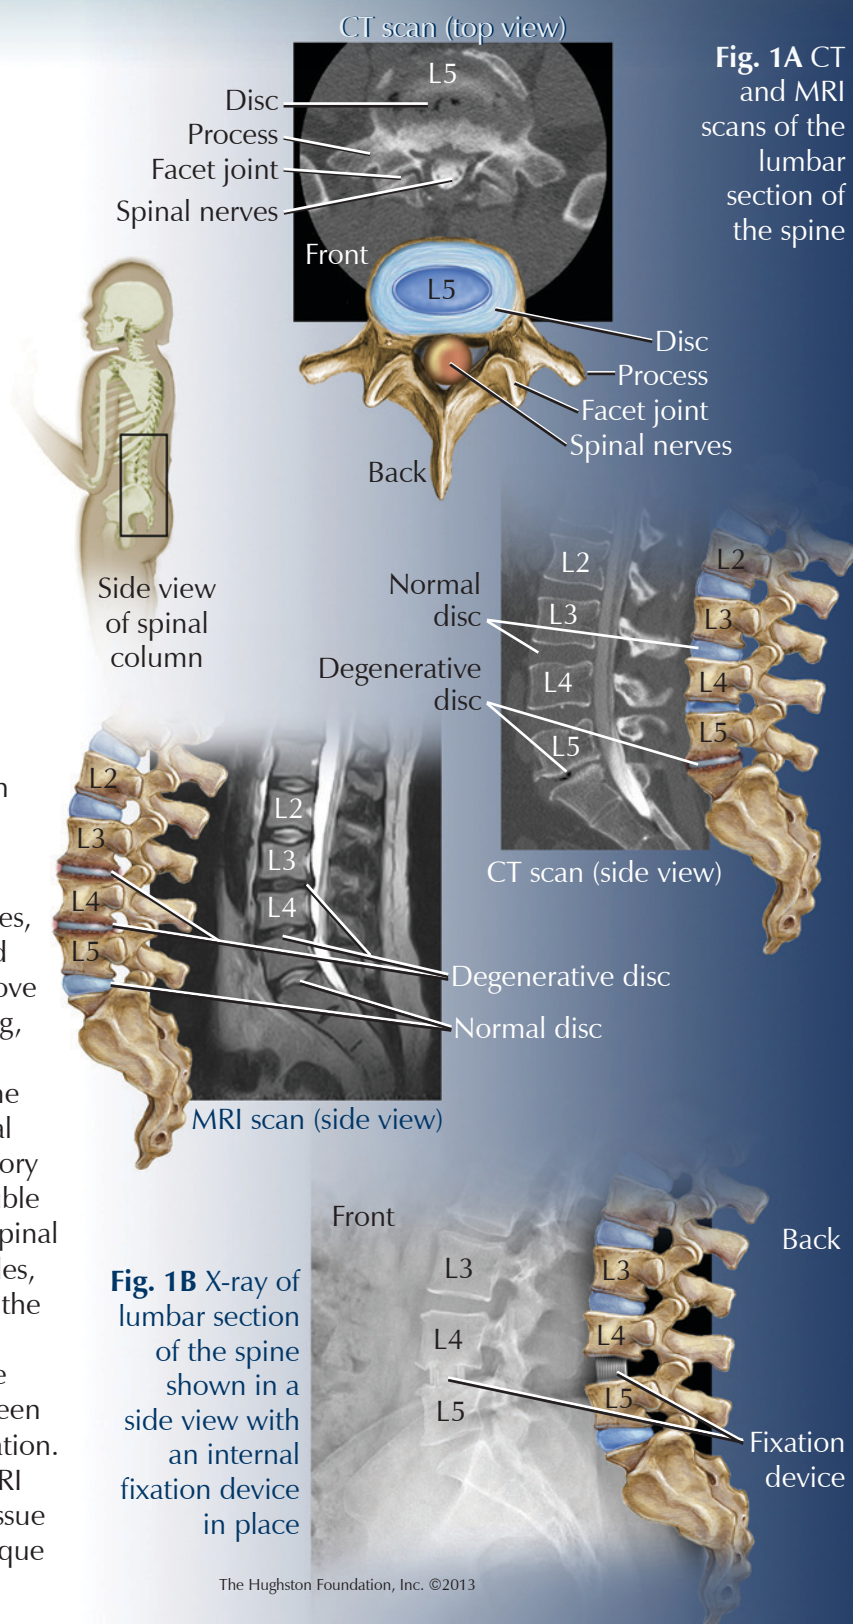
X-ray of lumbar section of the spine shown in a side view with an internal fixation device in place
